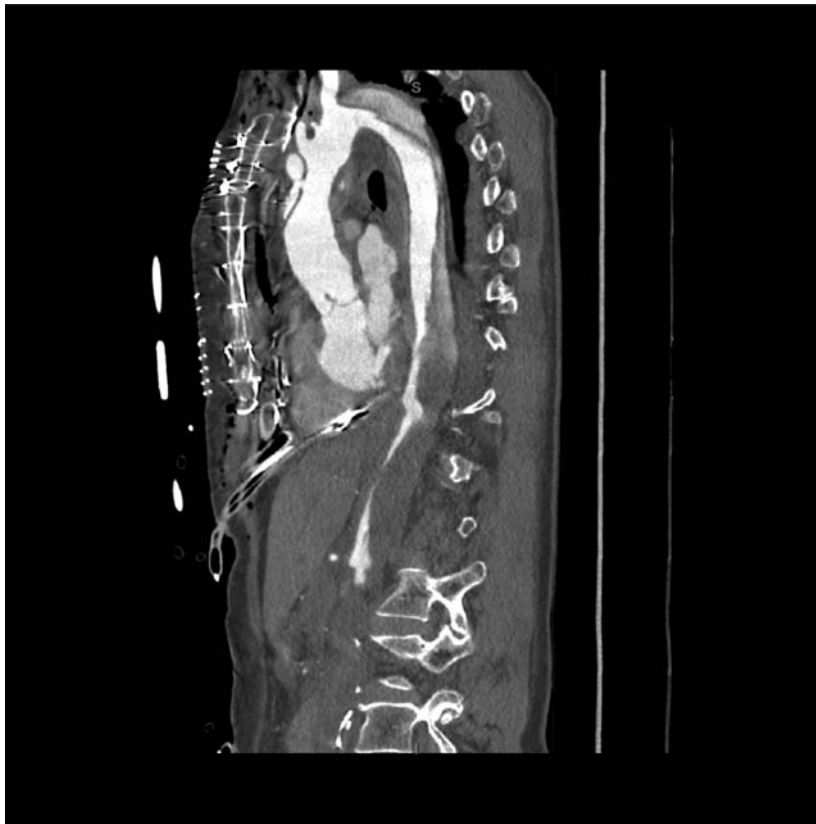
Angio-computed tomography scan on sagittal view showing an acute Type A aortic dissection with complete malperfusion of inferior mesenteric and iliac arteries.
